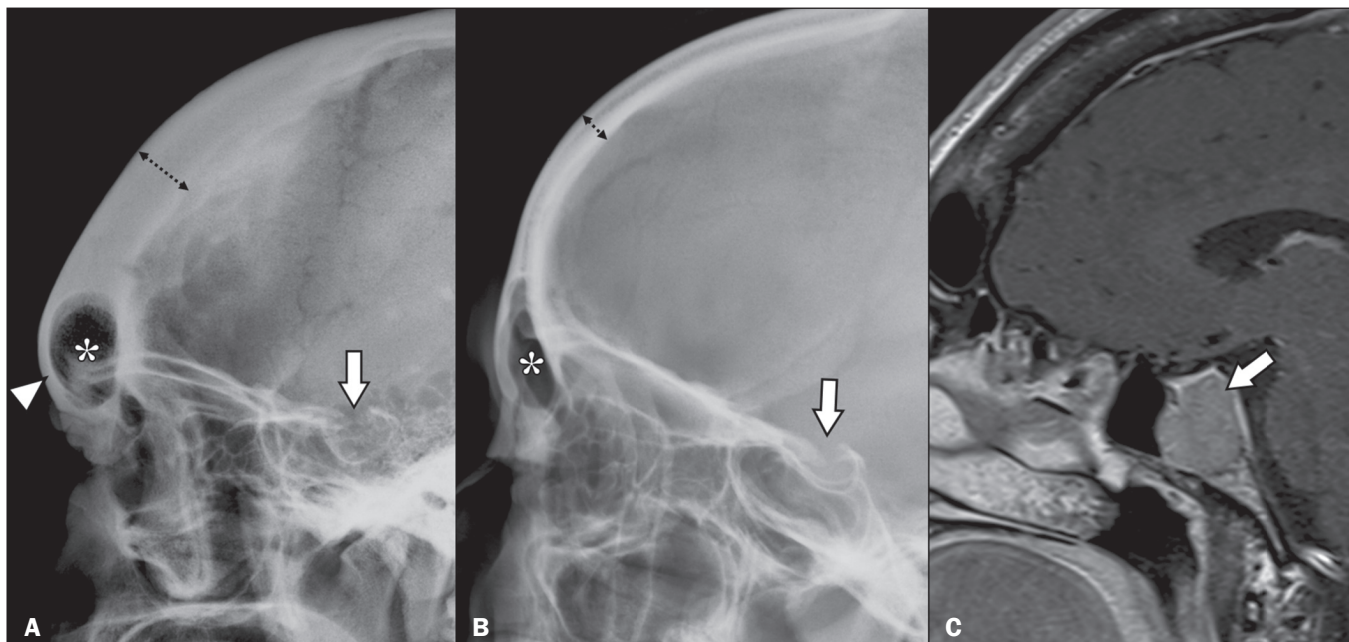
A: Radiograph of the skull, in a lateral view, of a patient with acromegaly, showing increased thickness of the frontal bone (dotted arrow) and forehead prominence (arrowhead), as well as increased dimensions of the frontal sinus (asterisk) and enlargement of the sella turcica (arrow). B: Lateral radiograph of the skull of a healthy patient, with preserved frontal bone thickness (dotted arrow), as well as normal dimensions of the frontal sinus (asterisk) and sella turcica (arrow). C: Gadolinium contrast-enhanced, fat-saturated, sagittal T1-weighted magnetic resonance imaging scan of the same patient depicted in panel A, showing pituitary macroadenoma (arrow), which was responsible for the enlargement of the sella turcica.
